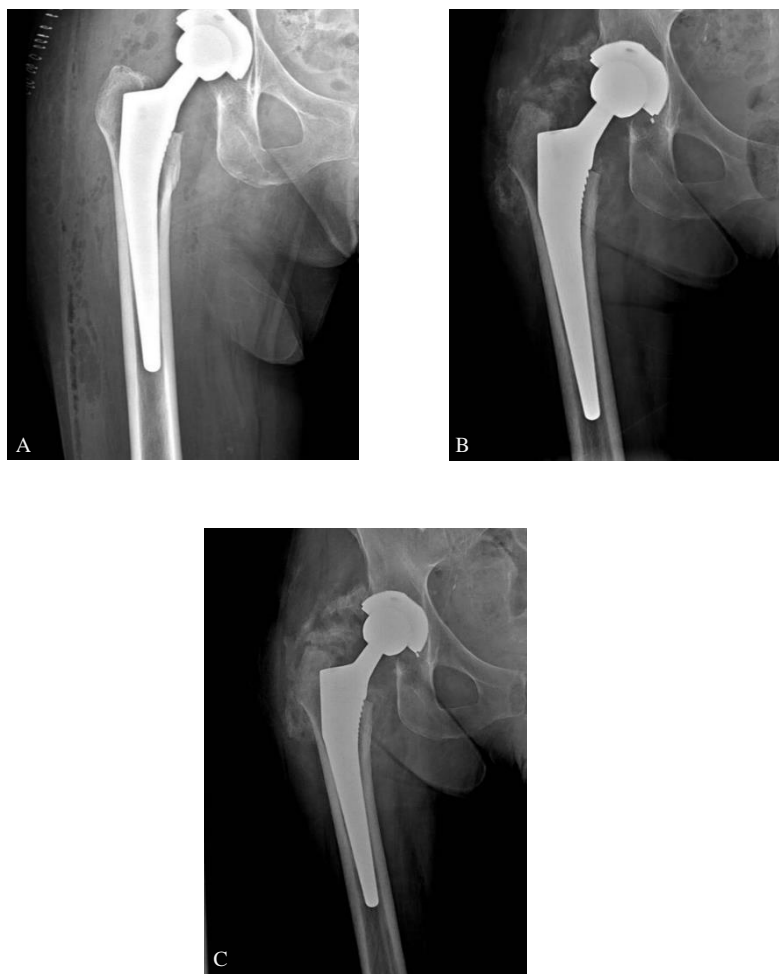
Radiographic control post-intervention of arthrolysis and clinical control at 1-month postarthrolysis.
